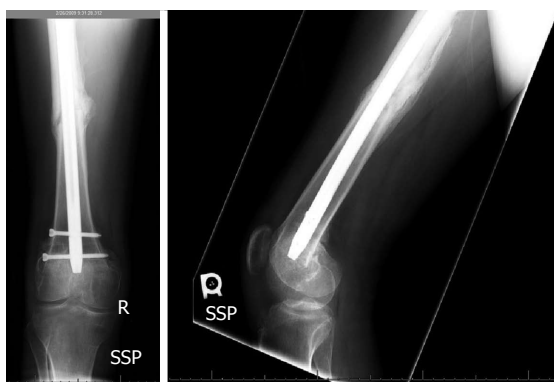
Anteroposterior and lateral radiographs showing healed diaphyseal femur fracture.
